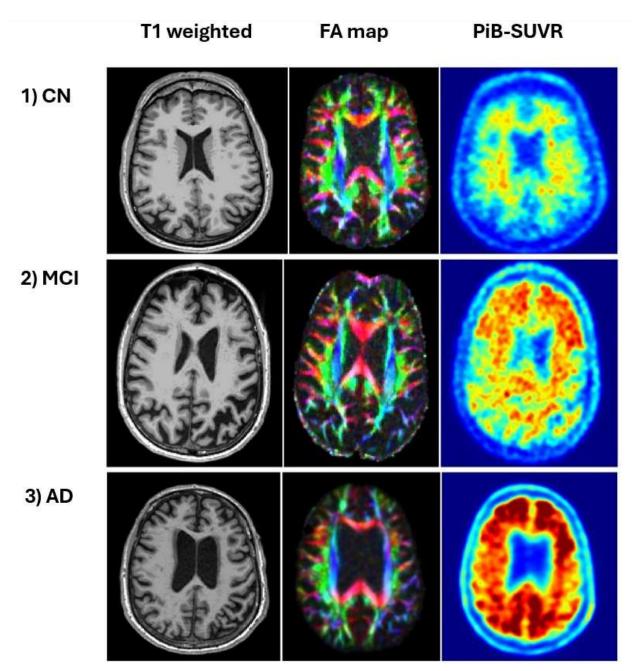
Three case examples from our data <sup>9</sup>, representing different stages along the AD continuum: cognitively normal (CN), mild cognitive impairment (MCI), and Alzheimer's disease (AD). A T1-weighted (T1w) MR image, fractional anisotropy (FA) map from diffusion tensor imaging (DTI), and [11C] Pittsburgh compound B (PiB) standardized uptake value ratio (SUVR) image are shown for each participant. 1) CN (69-year-old male): T1w MR shows no significant atrophy with a mean ALPS index of 1.26. PiB SUVR image shows off-target binding of the amyloid tracer to white matter, indicating amyloid negativity. 2) MCI (70-year-old male): T1w MR shows mild cortical atrophy, particularly in the left parietal lobe, with a mean ALPS index of 1.21; PiB SUVR shows amyloid deposition, particularly in the frontal lobes. 3) AD (71-year-old male): T1w MR shows cortical atrophy primarily in the right frontal and bilateral parietal lobes, with a mean ALPS index of 1.13; PiB SUVR shows marked cortical deposition of amyloid.
